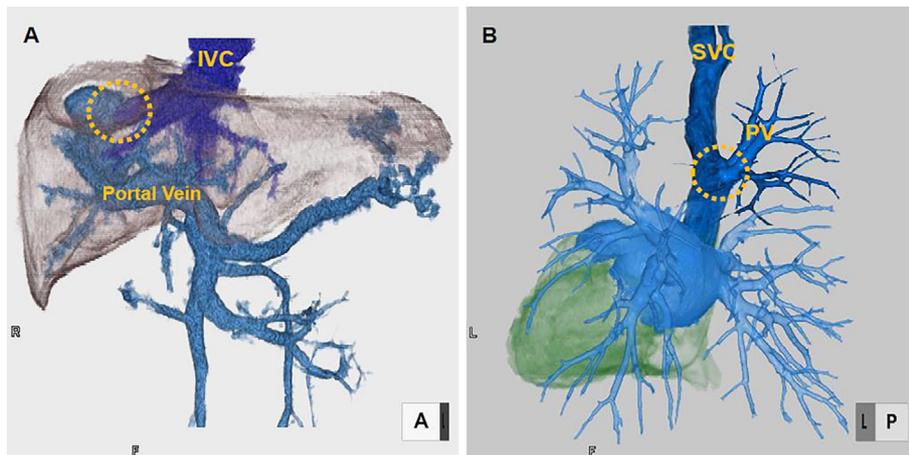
(A) Portosystemic shunt from the right portal vein to the right hepatic vein in the right lobe of the liver and (B) 3DCT imaging of PAPVR from the right pulmonary vein to the superior vena cava (posterior view). IVC: inferior vena cava, PAPVR: partial anomalous pulmonary venous return, PV: pulmonary vein, SVC: superior vena cava, 3DCT: 3-dimensional computed tomography
